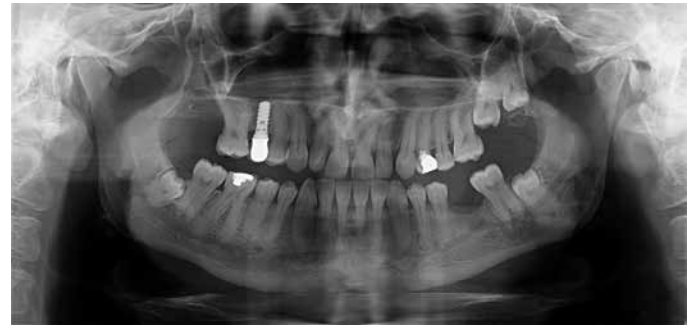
Panoramic radiography taken two years after the surgical removal of the displaced tooth.
